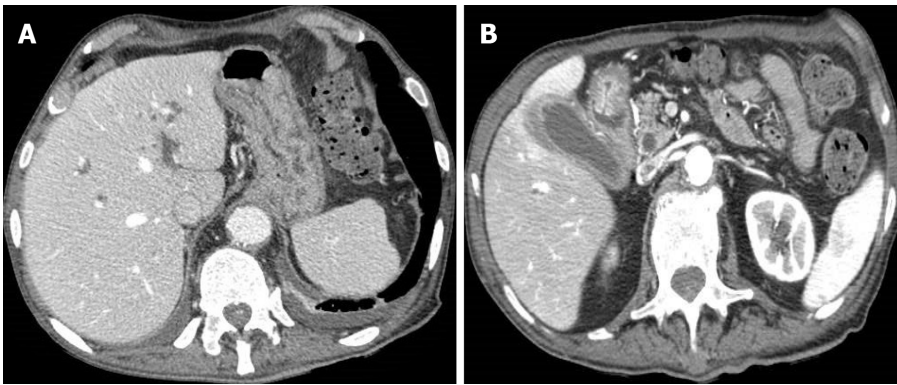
An 83-year-old woman with epigastric pain. A: Abdominal contrast-enhanced portal-venous phase computed tomography showed diffuse thickening of the submucosa of the gastric walls and intrahepatic biliary dilatation; B: Abdominal contrast-enhanced portal-venous phase computed tomography also depicts thickening of the submucosa of the pyloric region and signs of cholecystitis.
